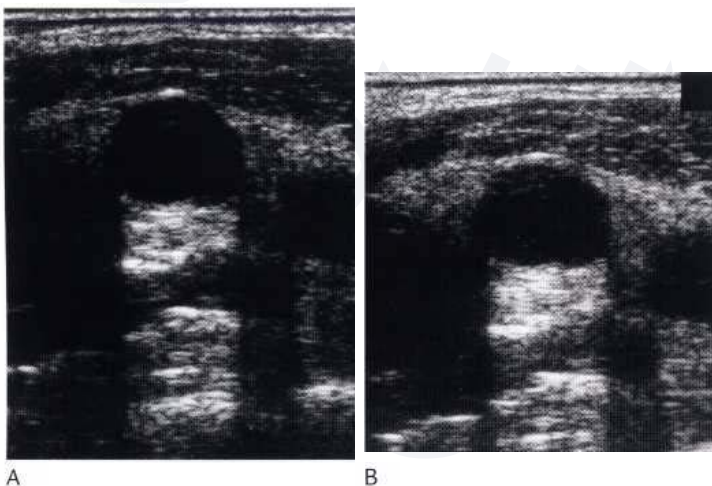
(A) Ultrasound scan of a neck node involved by lymphoma initially demonstrates a cystic-appearing mass. (B) The scan has been performed with increased gain settings and now some low-level internal echoes are seen.
